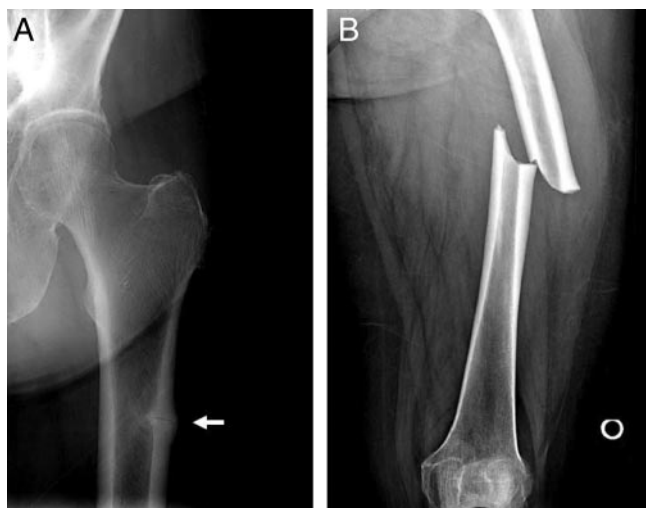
X-rays showing an impending femoral shaft fracture (A) and a representative atypical diaphyseal femoral fracture (B) with thickened cortices and a beak or spike. [Courtesy of J. Lane and A. Unnanuntana, Hospital for Special Surgery, New York, NY.]
